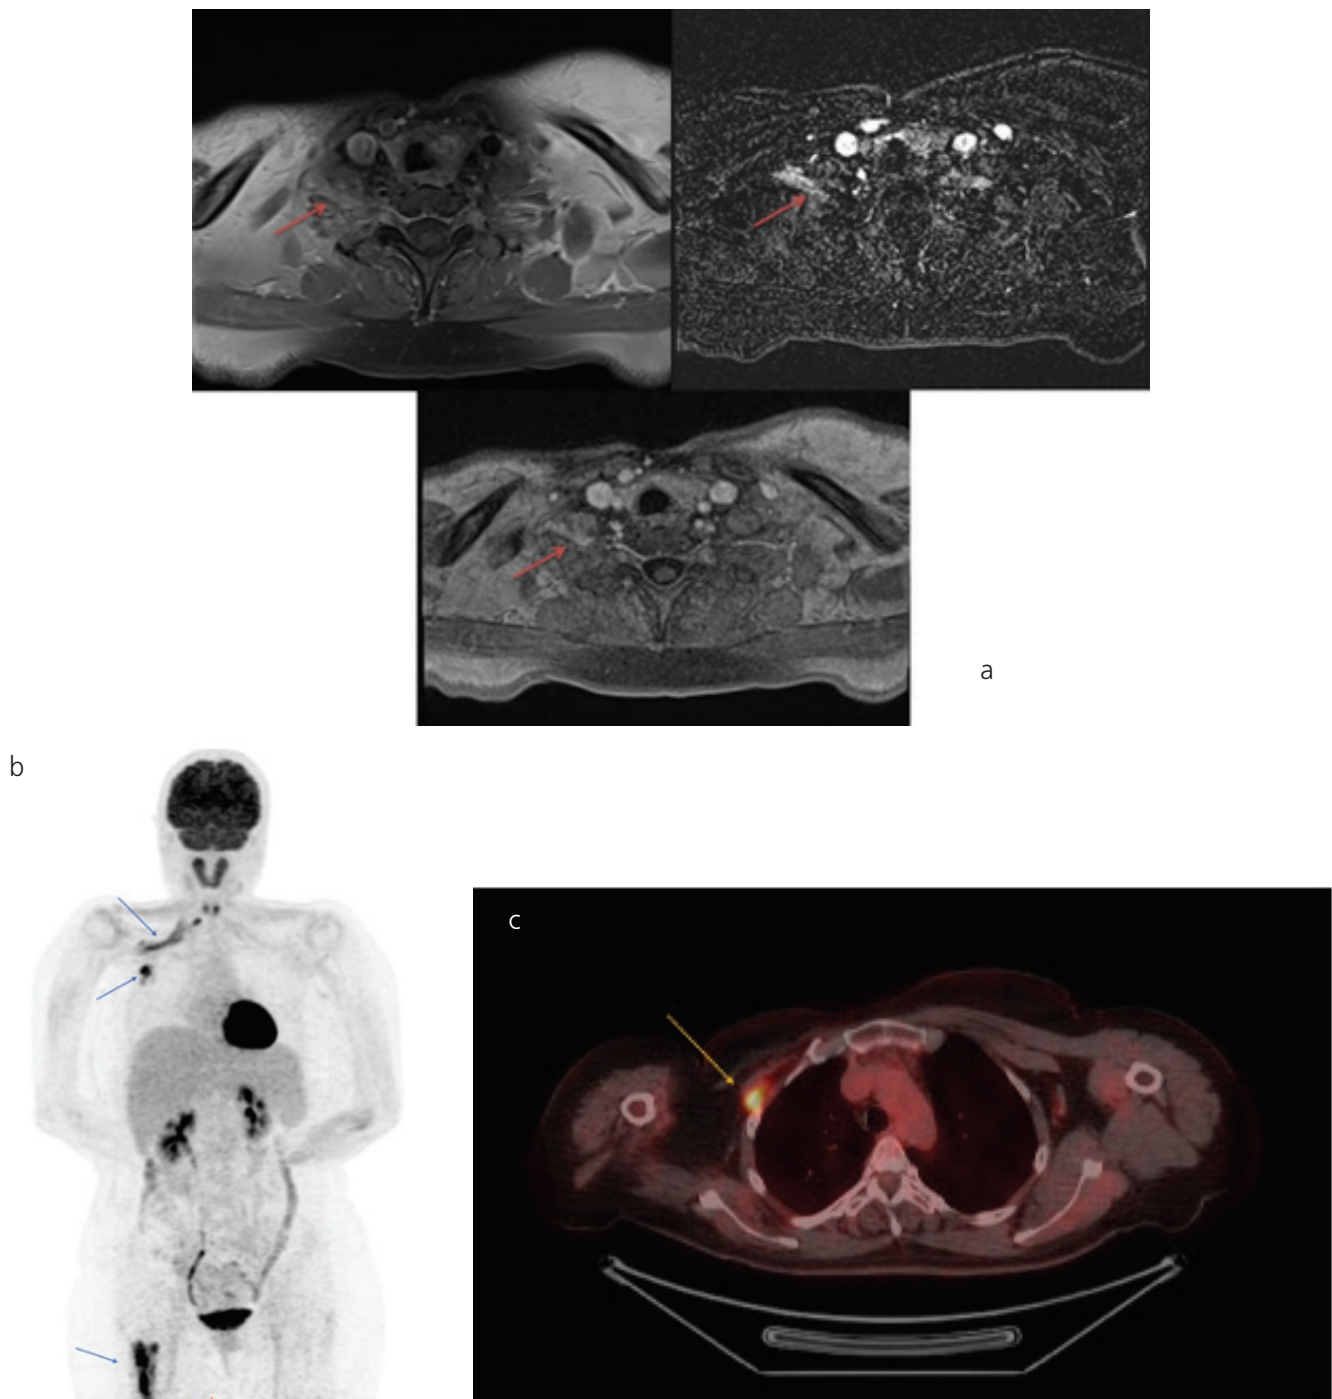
A 50-year-old woman diagnosed as having infiltrating ductal carcinoma of the right breast had undergone surgery (modified radical mastectomy and lymph node dissection), followed by adjuvant chemotherapy and radiotherapy six years ago. She presented to her oncologist with pain and restriction of movement of the right upper limb lately. Magnetic resonance imaging (MRI) was used for evaluation of brachial plexus and minimal thickening of plexus nerves was detected, which could be caused by radiation damage (Figure 1a, red arrows). The patient was referred for ¹⁸F-fluorodeoxyglucose (FDG) positron emission tomography/computerized tomography (PET/CT) for restaging of disease after it was observed that tumor marker level increased. ¹⁸F-FDG PET/CT was performed and maximum intensity whole body and fused transaxial images of thorax revealed linear pattern of pathological FDG uptake in the right lateral aspect of the upper chest, right axillary and interpectoral lymph nodes and right femur (Figure 1b and c, blue and yellow arrows).
